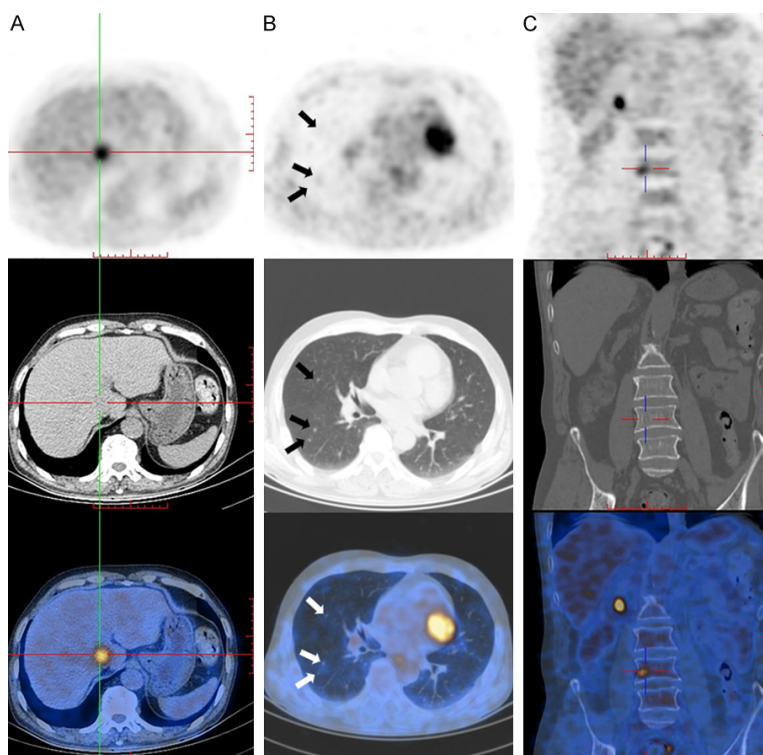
^{18}F -FDG PET/CT images. (A) The lesion in the caudate lobe of the liver with increased FDG uptake. (B) Several nodules in the upper lobe of the right lung with increased FDG uptake partially. (C) The lesion on the right side of the fourth lumbar vertebra with increased FDG uptake.
